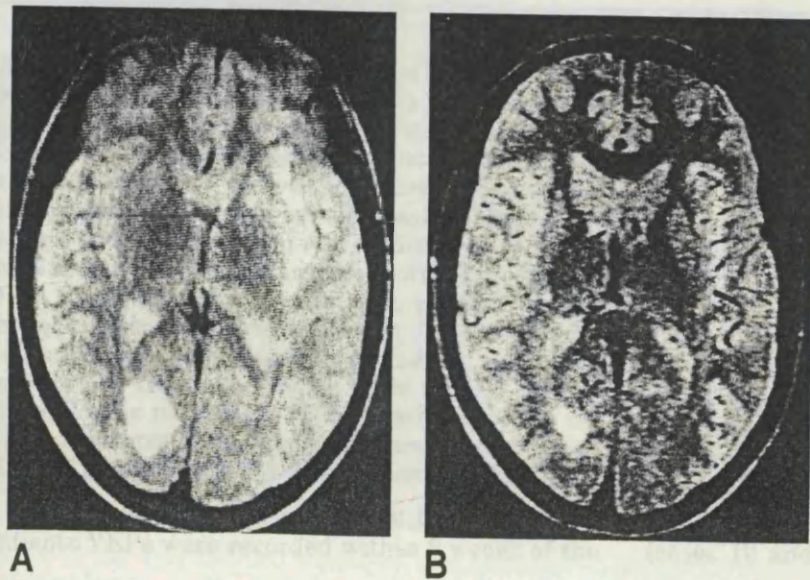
(Case 14) T₂-weighted MR images. (A) Two weeks after onset of an incomplete left lower quadrantic field defect. A large area of increased signal is seen in the right occipital white matter. (B) Twelve weeks later, the lesion is considerably smaller.
